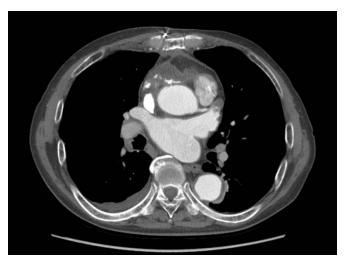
Postoperative computed tomography image showing that the pseudoaneurysm was successfully removed.
